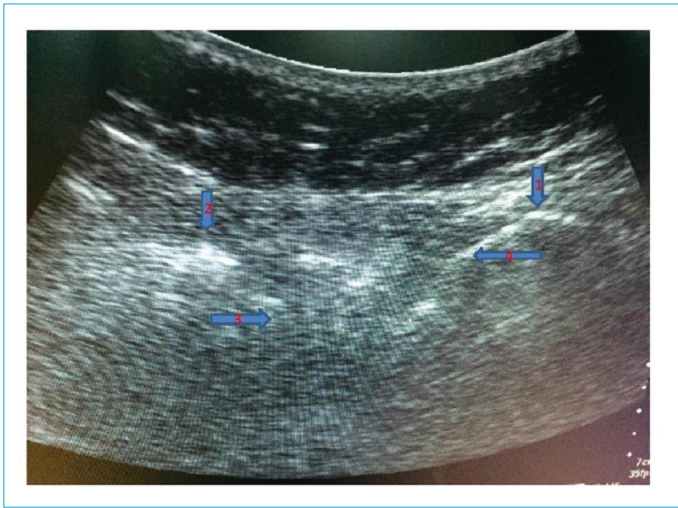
Ultrasound imaging of the spinal interval. Arrow 1: L5; arrow 2: L4; arrow 3: epidural space; arrow 4: ligamentum flavum.
